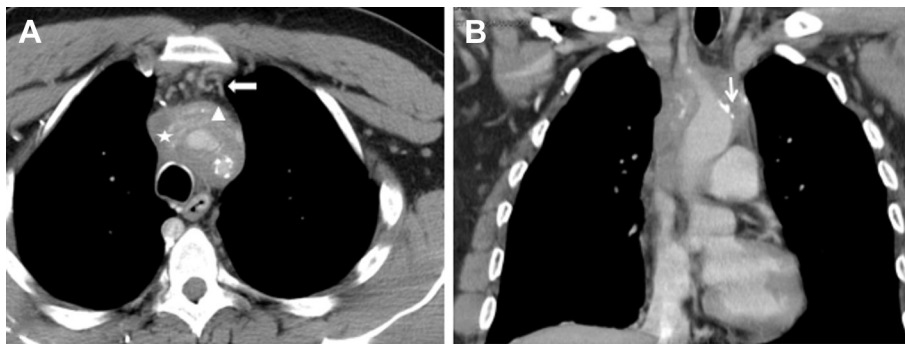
Axial (A) and coronal (B) contrast enhanced CT scan images demonstrate infiltrating soft tissue mass encasing the vessels in upper mediastinum. A, There is obstruction of the superior vena cava (star) and left brachiocephalic vein (triangle) with development of collateral vessels (thick white arrow) in anterior mediastinum. B, Portions of the mass contain calcification (thin white arrow).
